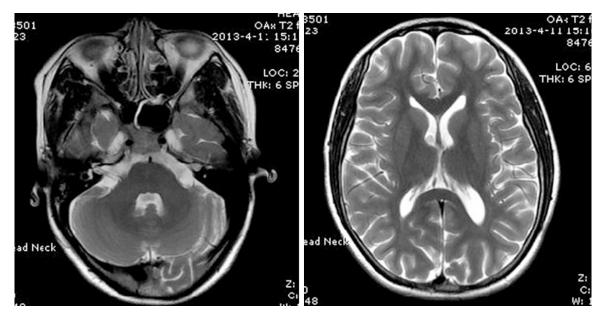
Cranial magnetic resonance imaging results. Meningeal enhancement was in bilateral temporal dura mater and tentorial, in accordance with meningeal leukemia.
